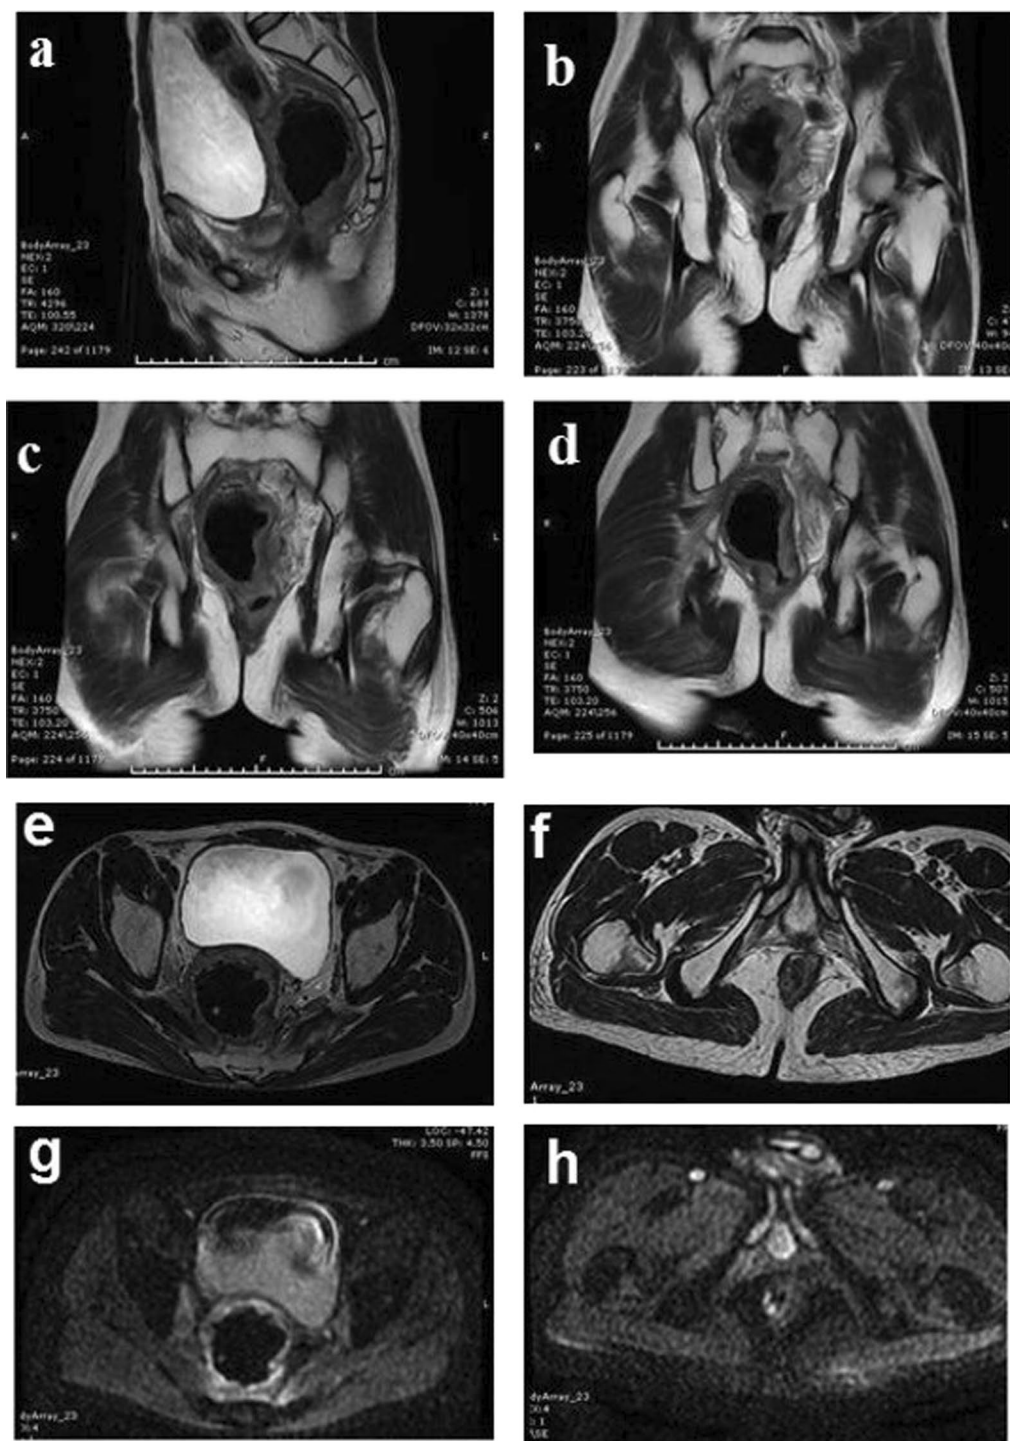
a–h MRI study for a 30-year-old male with rectal adenocarcinoma of the rectum and received CRT. a–d Sagittal, Coronal and e–f axial T2 WIs (g–h) DWIs revealed: Irregular circumferential mural thickening of the middle and lower rectum is seen reaching maximum thickness of 2.7 cm and extending for 7.6 cm in length, it start 3.8 cm from the anal verge, the mass lesion is seen infiltrating the right aspect of meso-rectal fascia, it elicits intermediate T2 SI with free diffusion. Subtle focus of hyperintense signal on DWIs was noticed at the end of anal canal but not reported as a significant finding
